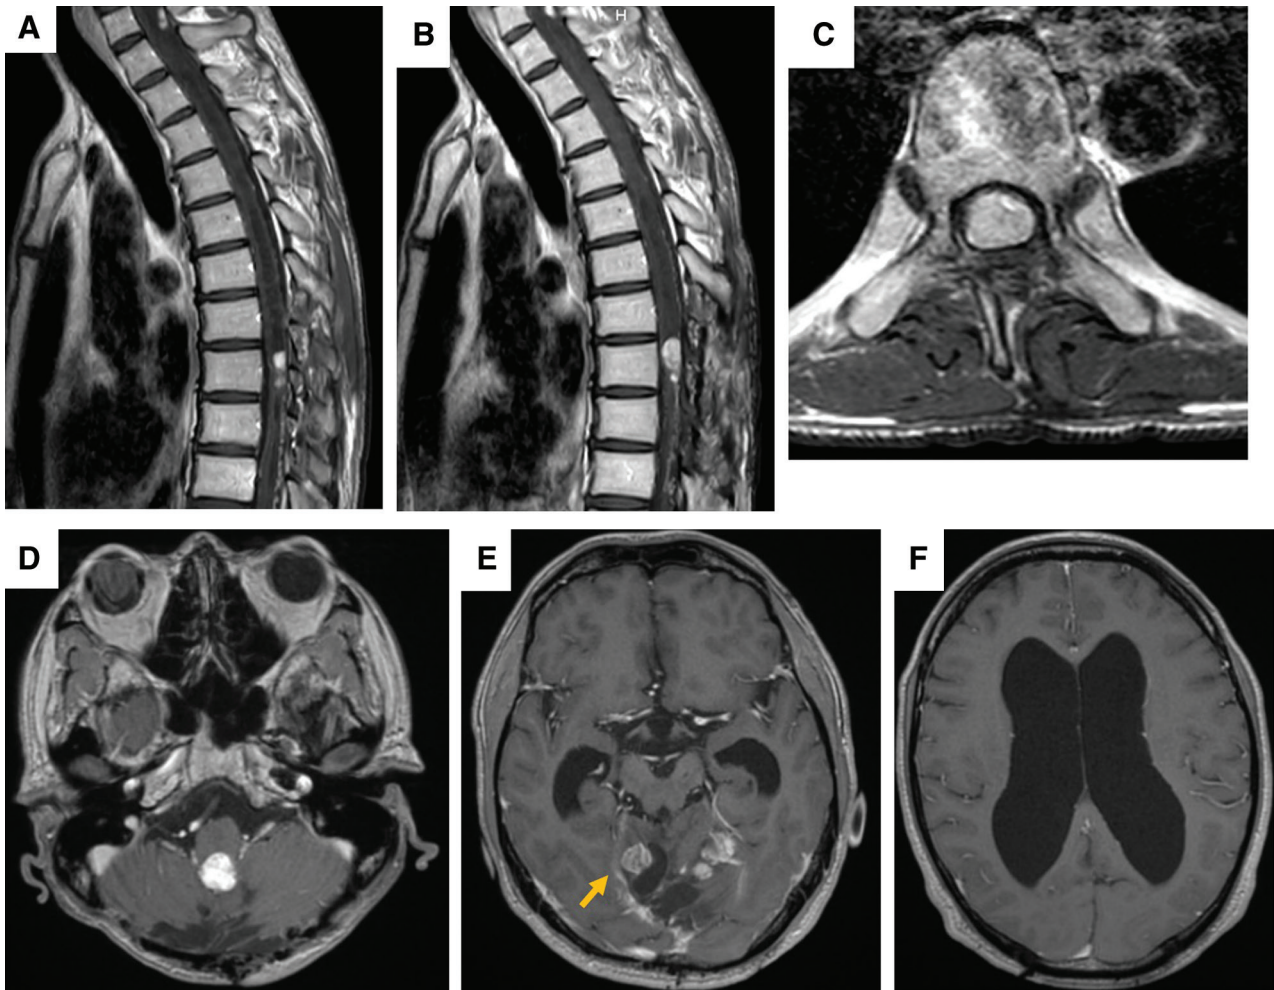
(A) Postoperative Gd-enhanced MRI of the spinal cord showing a small residual tumor in the Th8 region. (B) A sagittal and (C) an axial image confirming the presence of the residual tumor 18 months post-surgery. (D–E) Gd-enhanced brain MRI showing a newly appeared tumor in the cerebellar hemisphere (indicated by an arrow) and its ventricular enlargement (F). Gd: gadolinium, MRI: magnetic resonance imaging.
